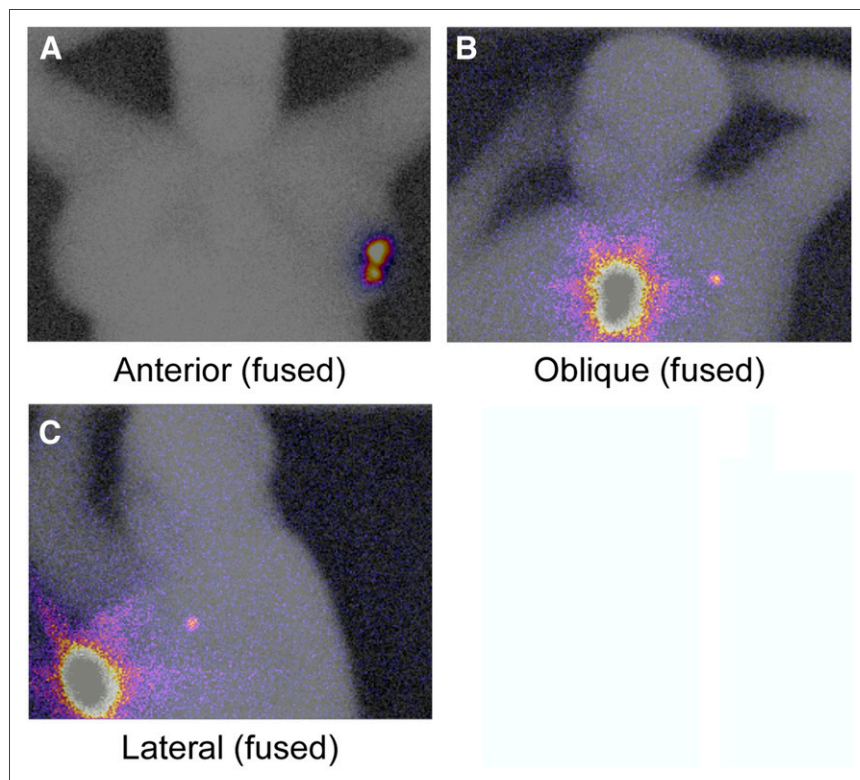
Example fused ^{99m}Tc (color) and ^{153}Gd (inverse gray scale) images from breast lymphoscintigraphy scan. ^{99m}Tc color window has been enhanced in oblique and lateral views to reveal lymph node with low tracer activity, which was not visible in anterior view and which would have had lower SNR if using ^{57}Co flood source and single energy window.
